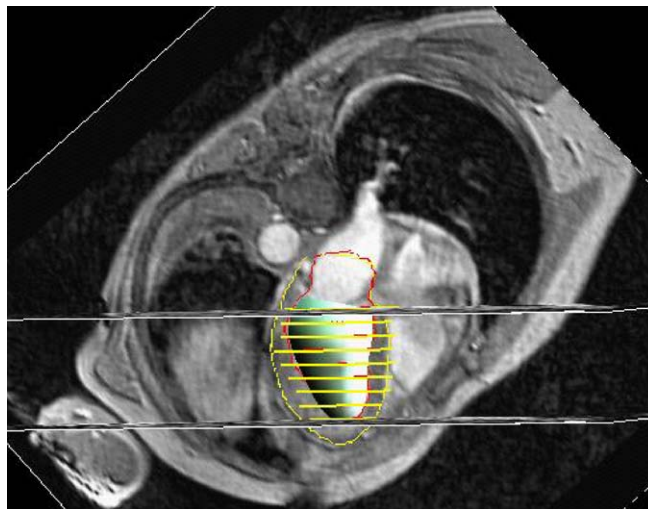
An example of diagnostic software based on physiome models. A 3D heart model is shown superimposed on a clinical MRI image of the heart and torso (Young, 1999). Figure is courtesy of Dr. Alistair Young of the Auckland Bioengineering Institute.
